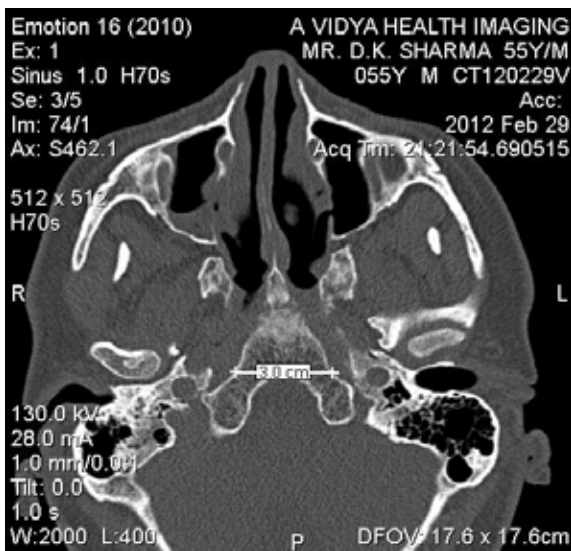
Showing measurement of Clivus width in an Axial view of an adult CT.
